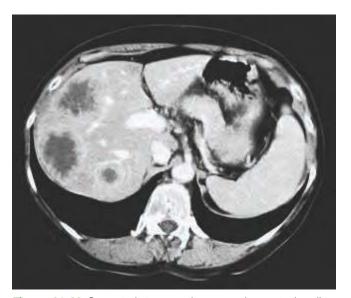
Computed tomography scan demonstrating liver metastases.
